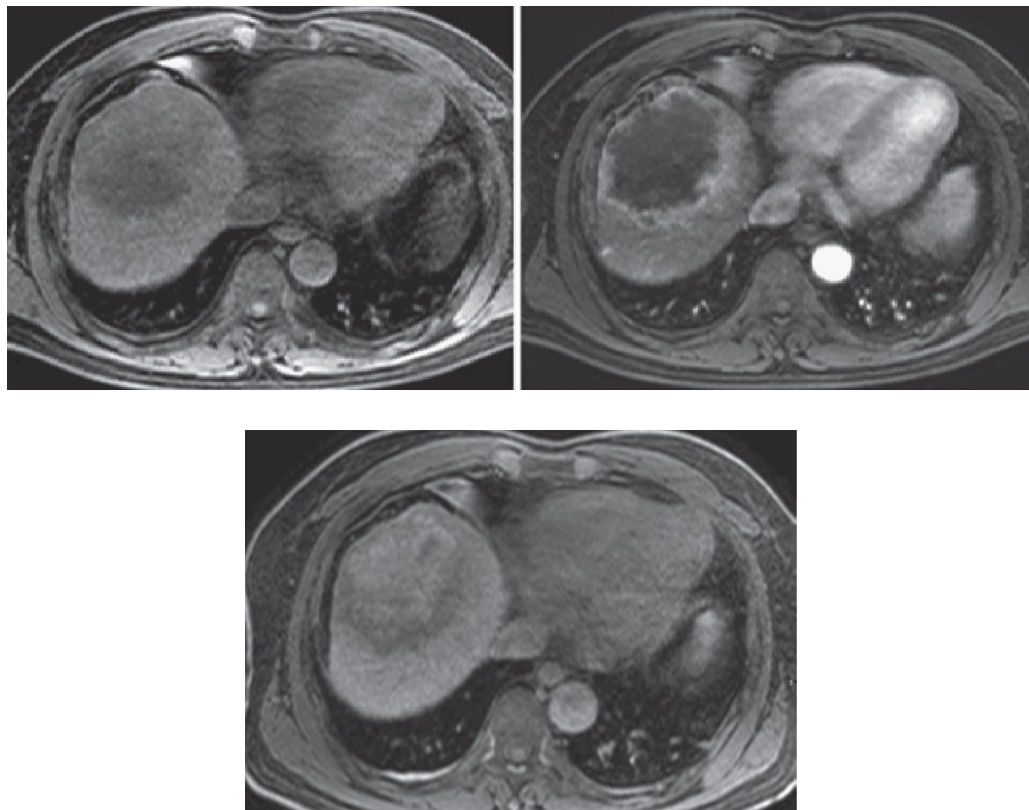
MRI showing peripheral hilar cholangiocarcinoma showing centripetal delayed enhancement.
